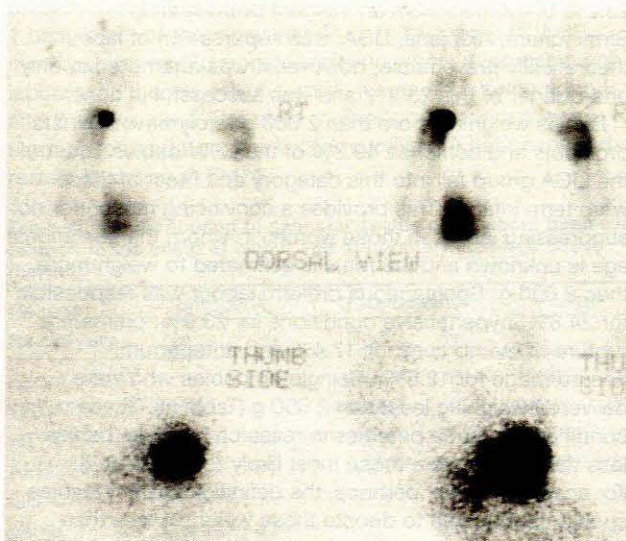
Scintigram of a patient with a negative radiograph showing increased uptake in the injured scaphoid.
